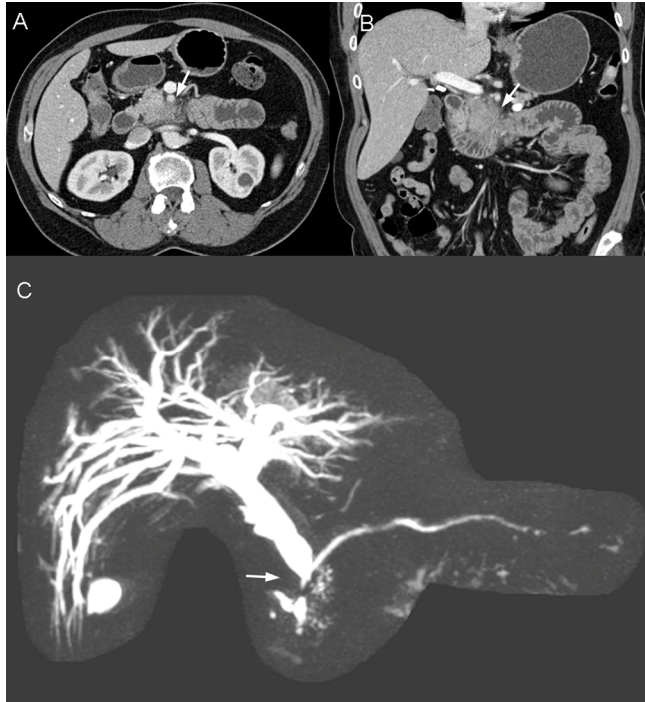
Review of a prior CT exam, performed two month prior to the parathyroid scan, showed soft tissue fullness of the head and uncinated of the pancreas suspicious for malignancy (A&B, arrows). MR cholangiography, following the parathyroid scan, confirmed the dilated biliary ducts from a progressing unresectable adenocarcinoma at the head of the pancreas with cut-off sign at the distal common bile duct (C, arrow).
